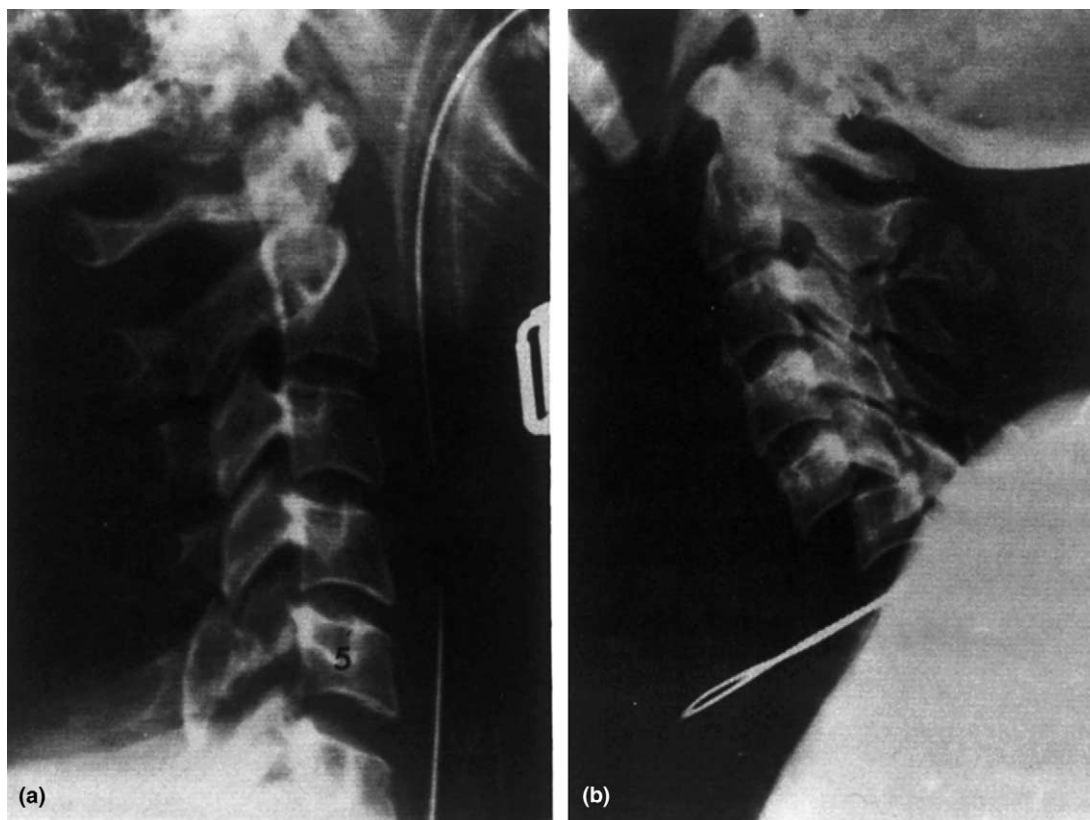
(a) Lateral cervical radiograph showing unilateral locked facet (flexion rotation) with minimal subluxation; (b) lateral projection showing bilateral locked facets with almost 100% subluxation at C5 on C6 unassociated with evidence of fracture (flexion distraction).
